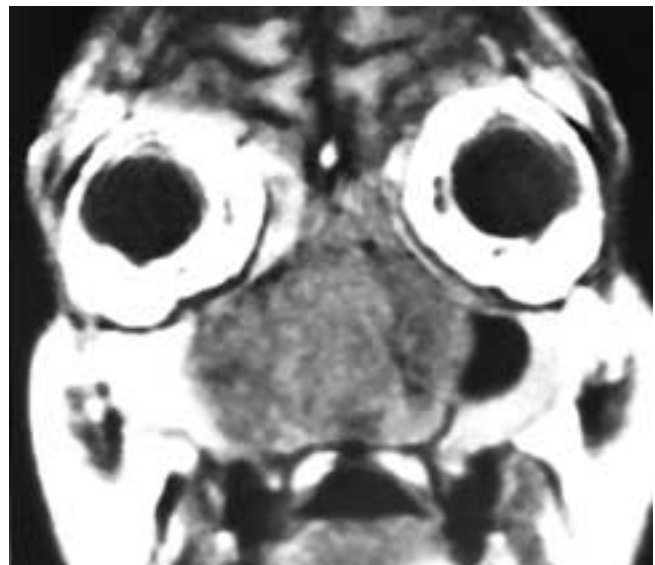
Coronal T1-weighted MR image shows an expansile bilateral nasal cavity mass that extends into the ethmoid and maxillary sinuses. The mass has a low to intermediate signal intensity and had a slightly higher T2-weighted signal intensity. This patient had a large cell lymphoma.
